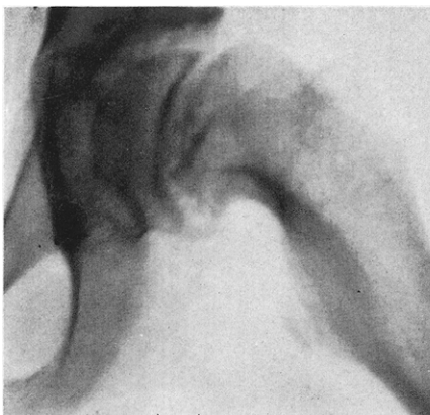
Case XI. Roentgenogram February 6, 1935; marked slipping of the head and bone destruction in the neck.
